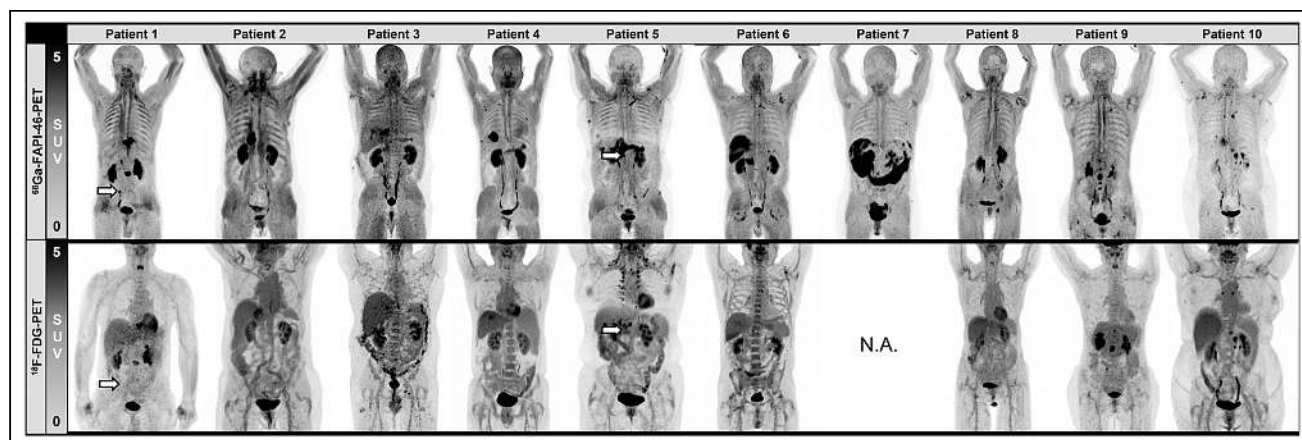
Maximum-intensity projections of ⁶⁸Ga-FAPI-46 and ¹⁸F-FDG PET for all patients. Tumor lesions that could not be detected by ¹⁸F-FDG PET are marked with arrows. Tumor sites are listed in Table 2. N.A. = not applicable.
